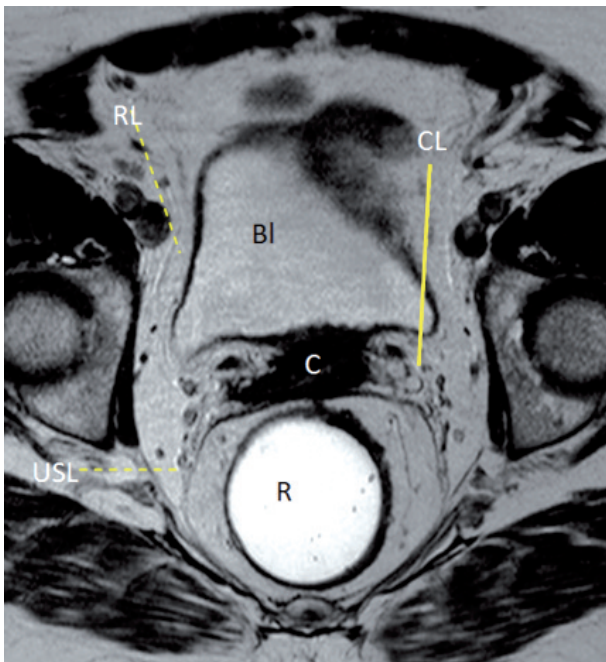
Axial T2-weighted TSE image taken at the level of uterine cervix showing the supporting structures of the uterosacral ligaments as thin curvilinear hypointense stripes coursing backward (*short dotted line*) and a portion of the round ligaments (*long dotted line*) coursing forward; the site of the cardinal ligaments is inferred by the presence of vessels, lymphatics and nerves (*long continuous line*). C= cervix; BL= bladder; R= rectum.
